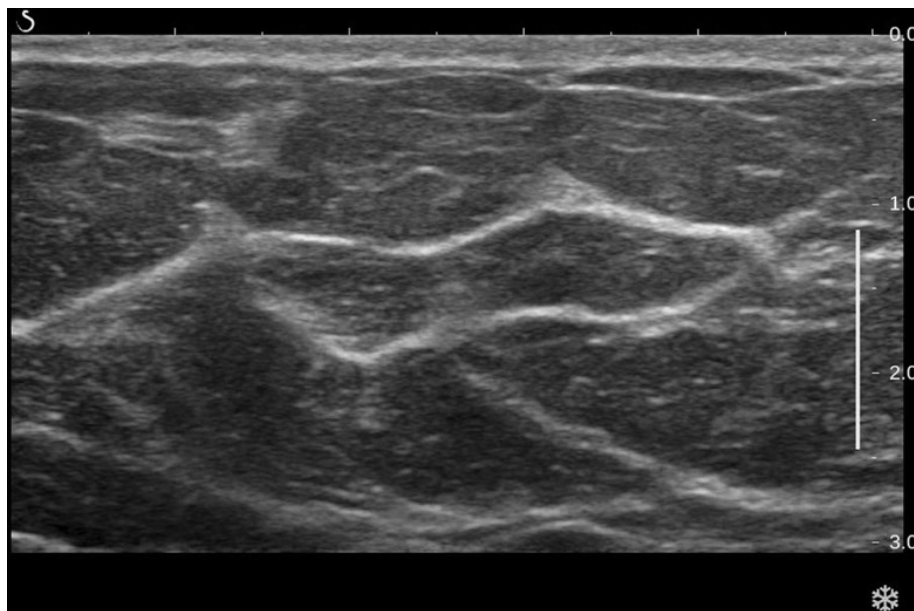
Sonographic image of the fatty breast, with dominantly hypoechoic fat lobules and Cooper ligaments visible as hyperechoic linear bands that traverse the fat.
